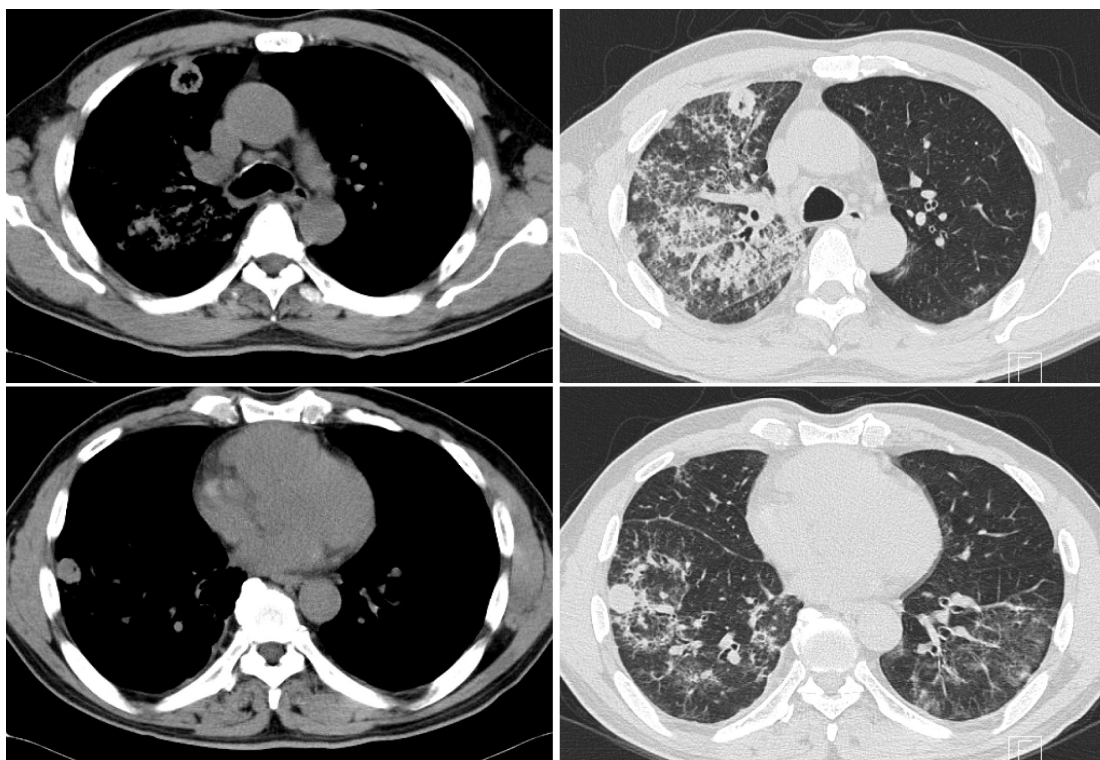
Chest computed tomography showing multiple cavitary nodules with ground-glass opacities in the right lung zones.
